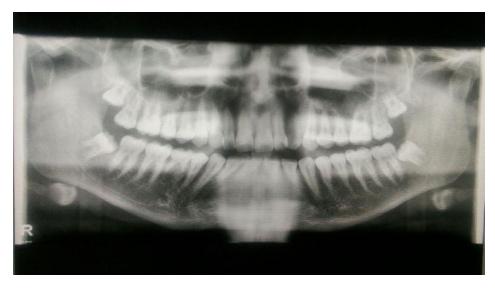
Orthopantomogram showing supernumerary teeth
